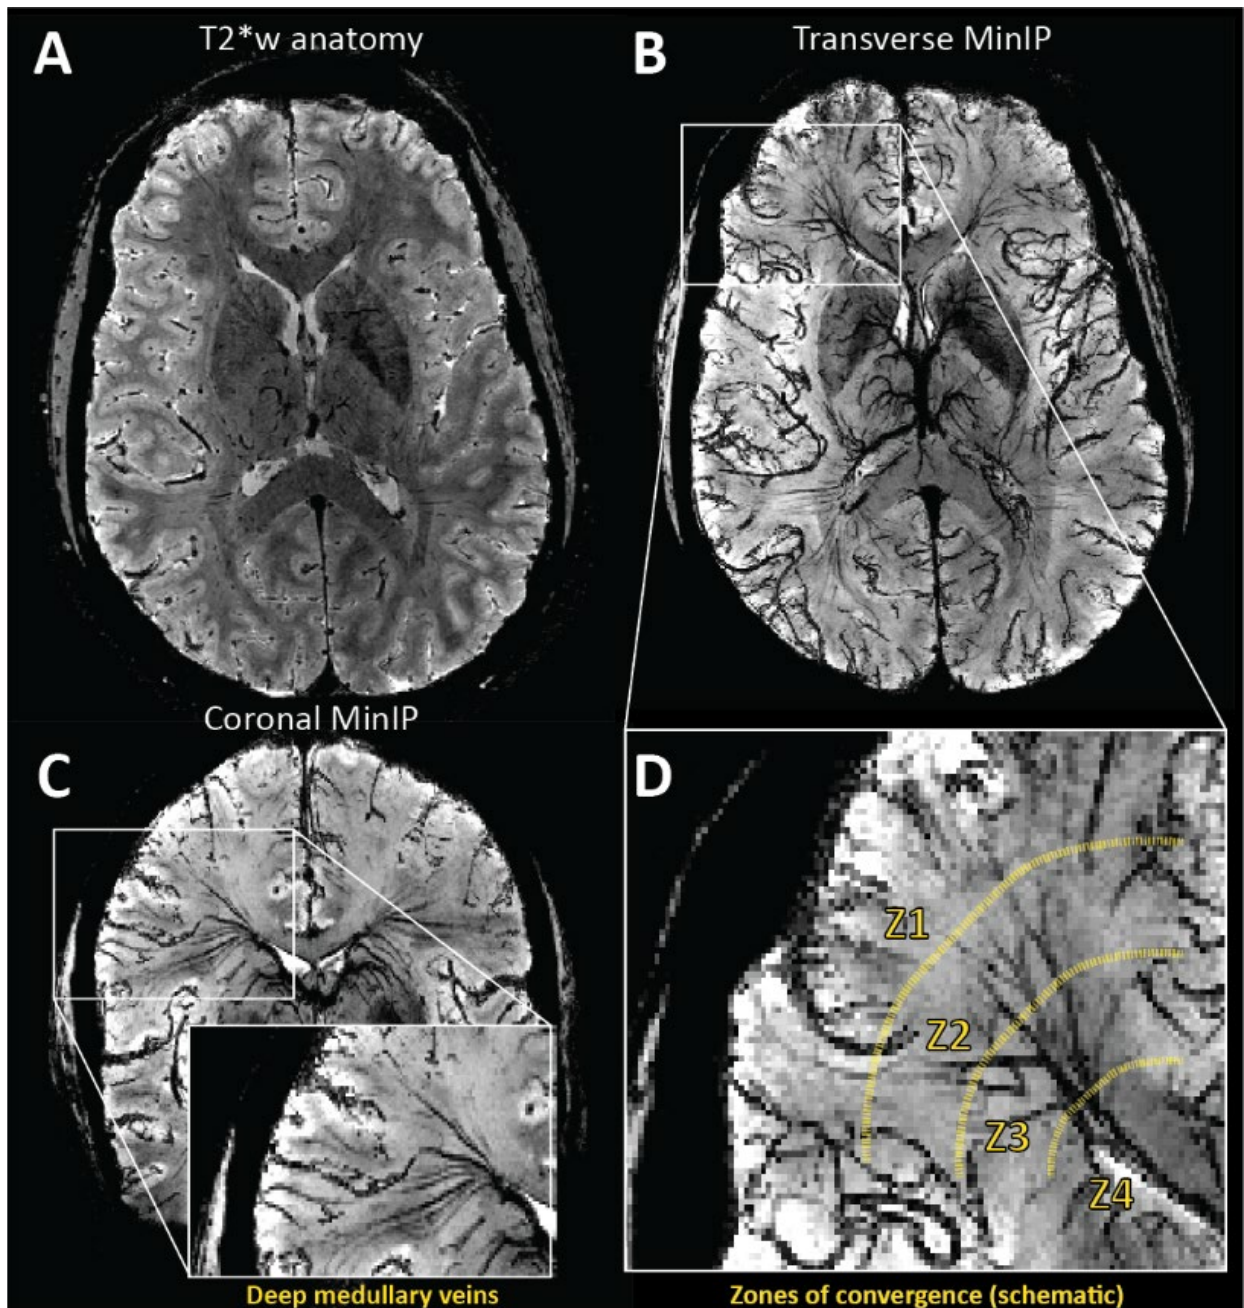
High-resolution T2\*-weighted anatomical image of a representative subject. Based on this volume, a minimum intensity projection image (MinIP) is generated using 9.5mm slabs. The transverse and coronal MinIP images are shown in figure 1B and 1C, respectively. The inlay in 1C highlights the radial pattern of the large medullary veins. These veins fan outward from the ventricles to penetrate deeper white matter tissue. The expanded image in figure 1D highlights branching patterns that can be attributed to distinct convergence zones. As described by Okodura et al.<sup>8</sup>, zone 1 is characterized by the presence of superficial medullary veins and smaller branching patterns known as coat-rack and bamboo-branch unions. These structures are too fine to be resolved using MR imaging. The transition to zone 2 is mainly characterized by the candelabra structures created where laterally running tributaries converge with deeply running medullary veins. These deep medullary veins course through the third convergence zone to form palm-like unions with subependymal veins forming the fourth zone of convergence at the lateral ventricle.
